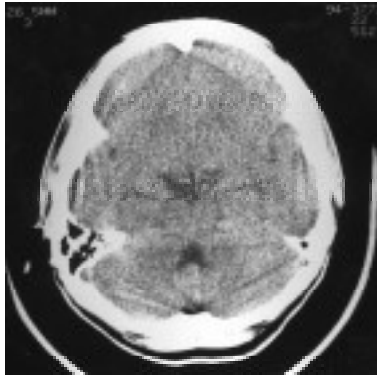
Previous unenhanced CT scan of same patient as Fig. 1 shows a small area of high signal attenuation (arrows) in the subcortical area of the right frontal lobe.
